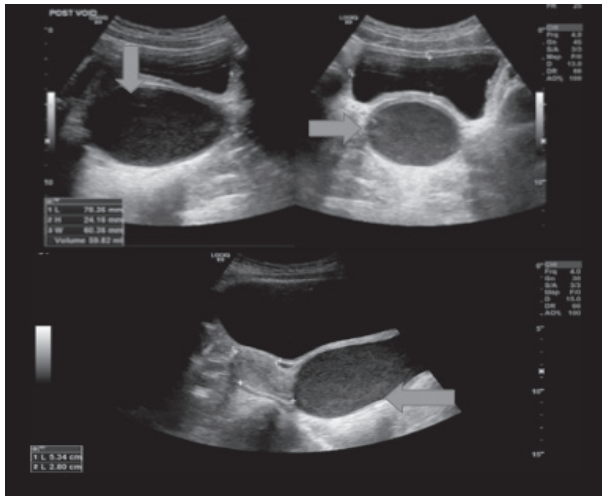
Pelvic Ultrasound: A Large Turbid Fluid Filled Structure Posterior to the Bladder Measuring 5.3 x 2.8 cm. Related to the Vagina Suggesting Hematocolpos
